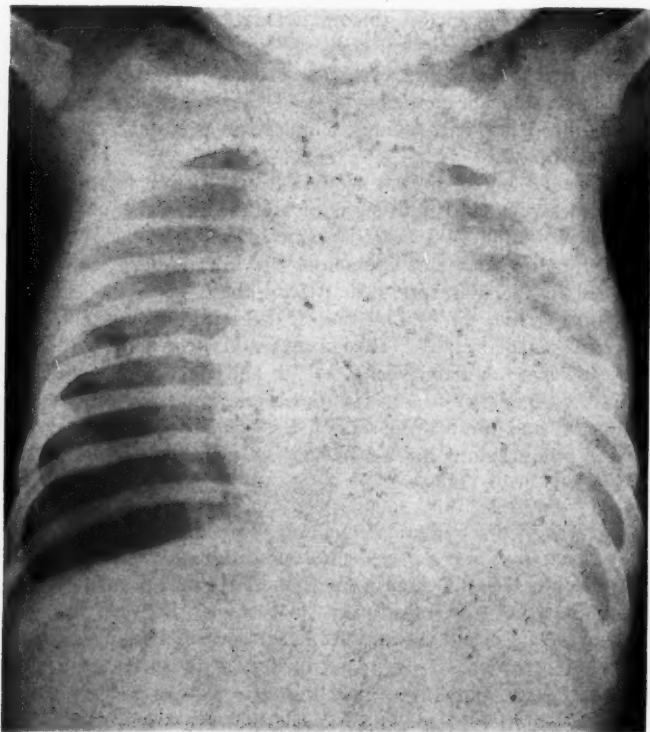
X-ray of chest showing enlarged heart and pneumonitis.
